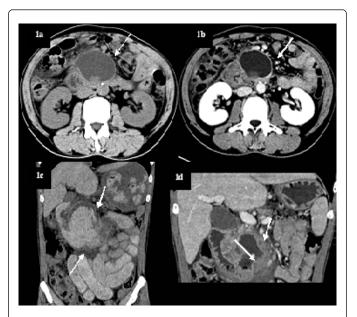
a) and b) Pancreatic pseudocyst by abdominal CT examination; c) Large amount of blood noted in stomach, duodenum and small bowel; d) Follow-up CT show marked shrinkage of pancreatic pseudocyst and direct orifice of fistula.
